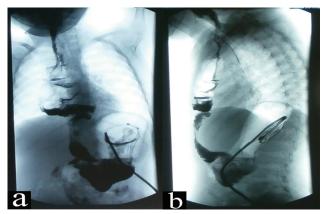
Plain (a) and lateral (b) contrast radiographies two weeks after pharyngoesophageal reconstruction with retrosternal colon interposition.
